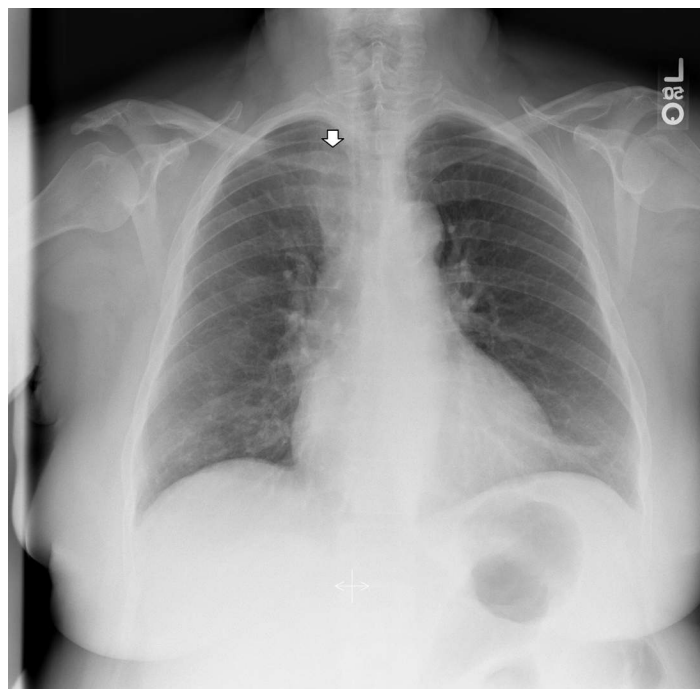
Chest radiograph of patient showing abnormality at the right sternoclavicular joint (arrow).
